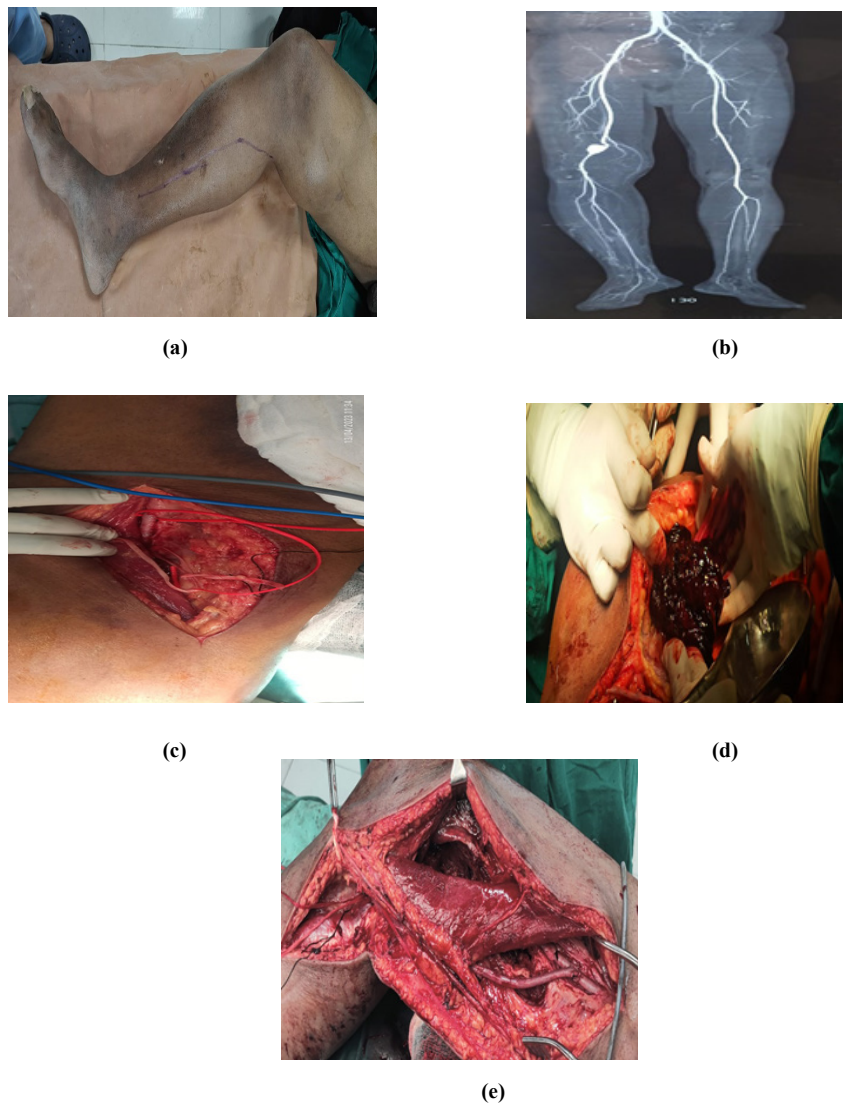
(a) Painful swelling near the right knee. (b) CT angio: 5.2*4.1*3.3 cm right proximal popliteal artery pseudo aneurysm. (c) SFA and distal PA control. (d) Thrombus removed, and sac evacuated. (e) SFA to distal PA bypass with opposite limb GSV.
